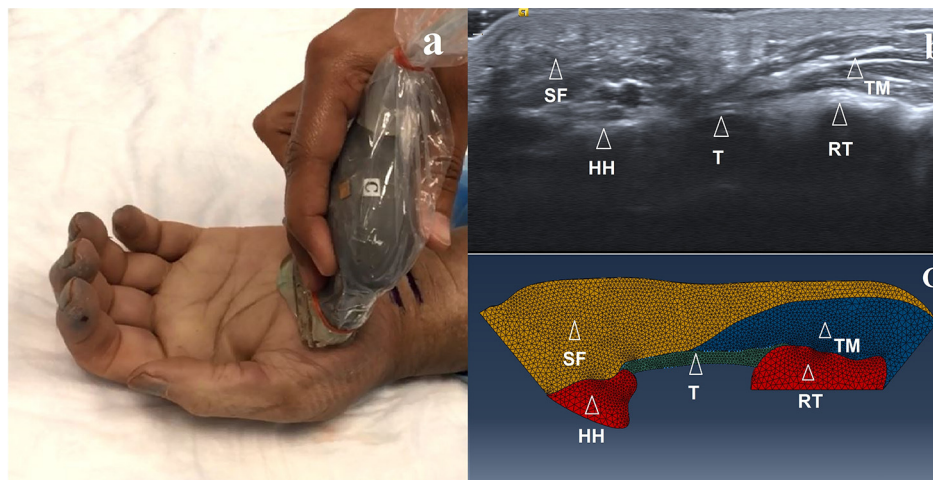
FE model of the volar carpal tunnel based on ultrasound image. (a) Ultrasound image collection of the distal carpal tunnel; (b) The ultrasound image showing thenar muscles, skin-fat, TCL, hook of hamate and ridge of trapezium (c) FE model components including hamate bone, trapezium bone, thenar muscles, skin-fat and TCL. SF: skin-fat; HH: hook of hamate; T: TCL; RT: ridge of trapezium; TM: thenar muscles.
